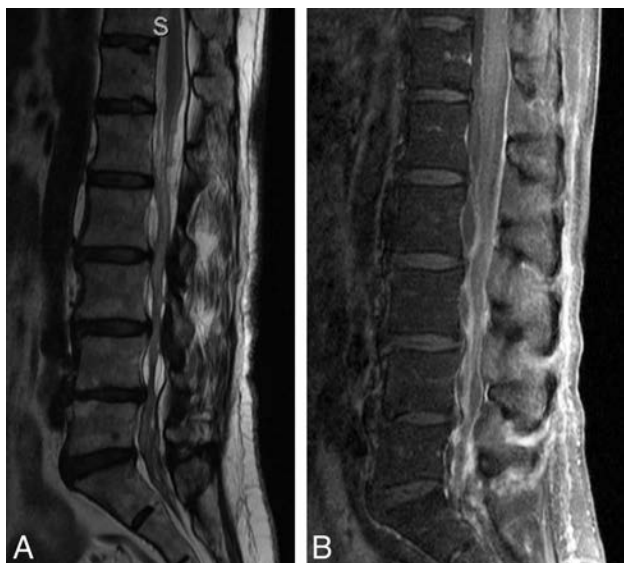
Adult patient with multiple epidural lumbar steroid injections, now recalcitrant to more injections. The patient experienced severe pain during an attempted LP. Note severe arachnoiditis. *A*, T2 sagittal MR image shows marked clumping of the cauda equina in the central thecal sac, but it also adhered to the posterior dural wall. The conus appears irregular, also from arachnoiditis. *B*, T1 sagittal, postgadolinium image with fat saturation shows diffuse enhancement of the nerve roots and meninges. Arachnoiditis does not always enhance. Because meningitis could have a similar appearance, CSF must be obtained to exclude infection, despite the arachnoiditis.
